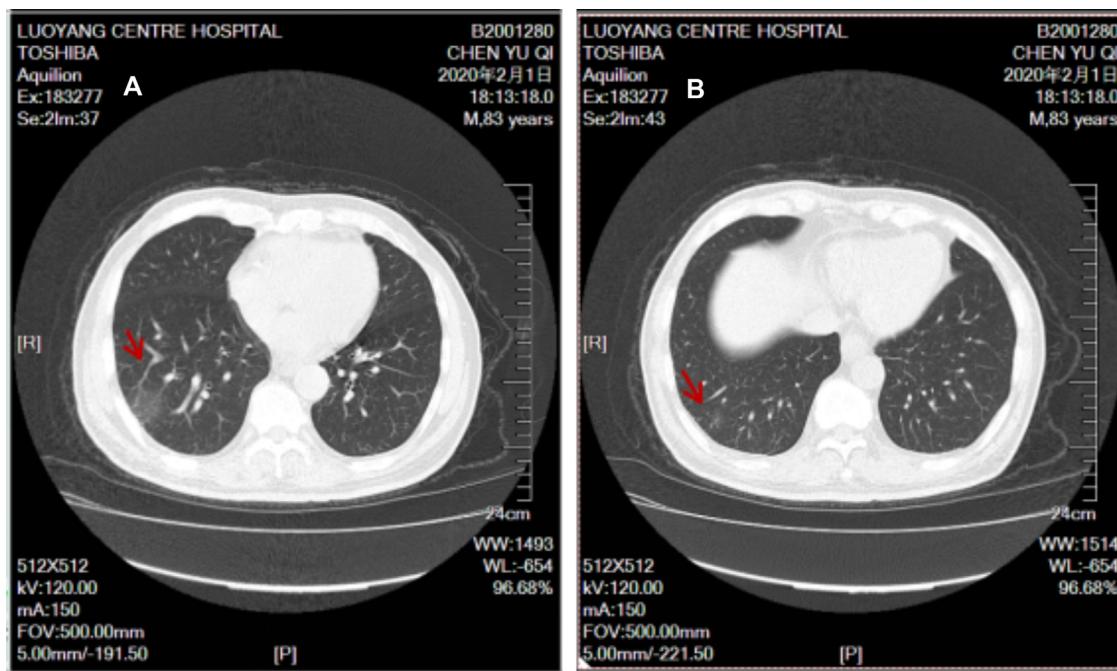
A and B. On February 1, computed tomography (CT) scan images revealed a single ground-glass opacity in the right lower lung lobe.
